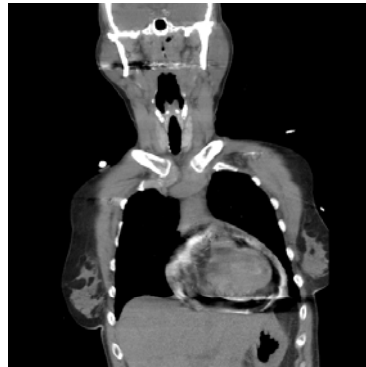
Coronal section of the CT scan showing significant pneumopericardium
